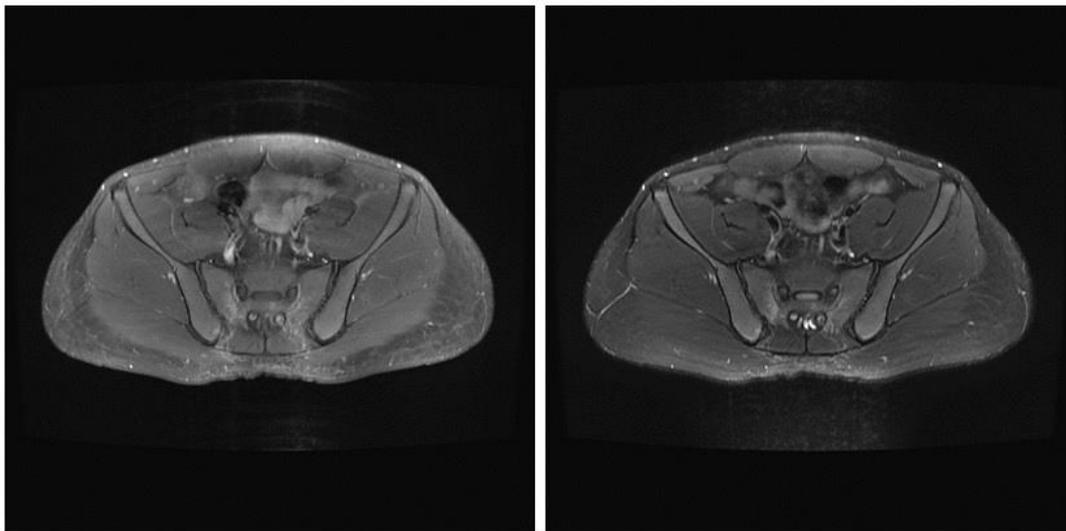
MRI of pelvis-The axial(T1 weighted-left, T2-weighted-right) views show the signal change with enhancement at left S2 nerve root.
